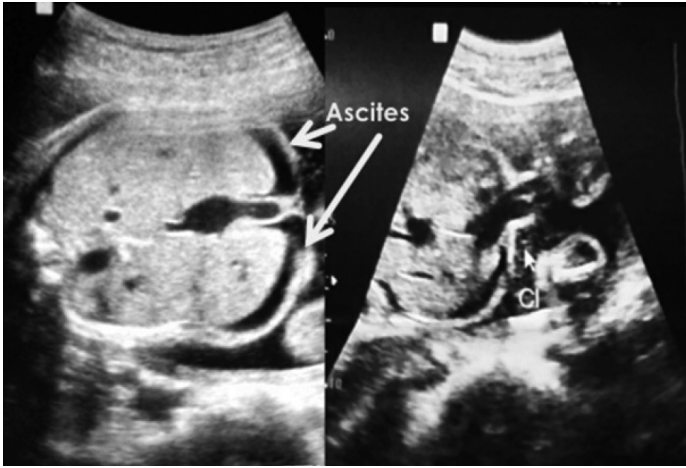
RIGHT: Congenital anomaly scan at 29 weeks age of gestation, showing mild ascites with intact diaphragm. There is a 3-vessel cord with intact cord insertion. Kidneys are normal in size and the bladder is fluid-filled; LEFT: Ultrasound done 4 days later, at 29 4/7 weeks age of gestation, showing progression of the fetal ascites as shown by the increased anechoic fluid in the fetal abdomen.
